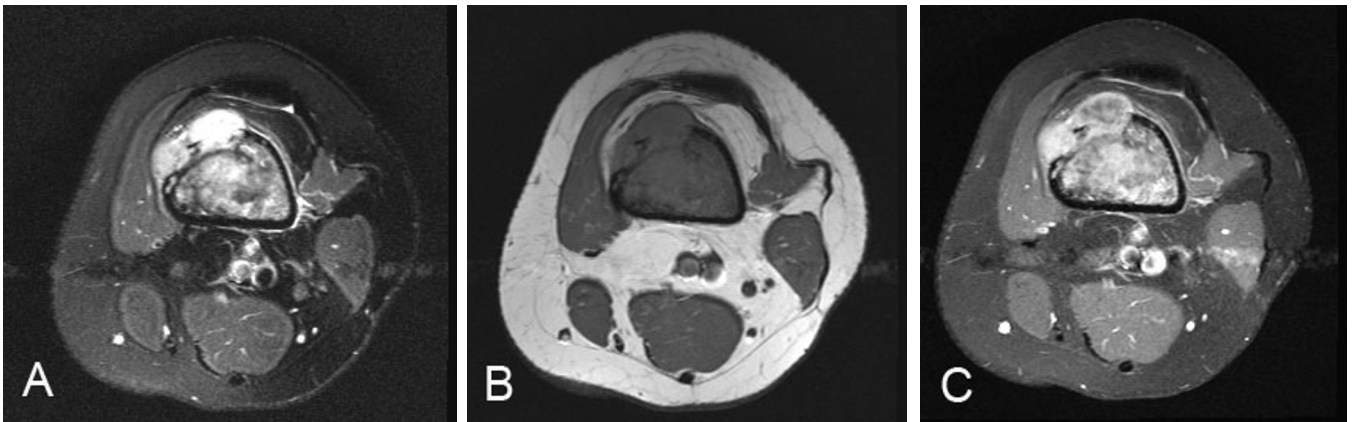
A. 28-year-old female with left-knee pain. Axial T2 fat-saturated MR image (TR = 5600, TE = 55) demonstrated heterogeneously hyperintense intramedullary mass with anterior cortical breakthrough and small soft-tissue mass. B. Axial T1 precontrast MR image (TR = 750, TE = 10) demonstrated T1 hypointense mass replacing the femoral marrow with anterior cortical breakthrough and small soft-tissue mass. C. Axial T1 fat-saturated postcontrast MR image (TR = 786, TE = 11) demonstrates a heterogeneously enhancing intramedullary mass with anterior extracortical breakthrough and small soft-tissue mass.
